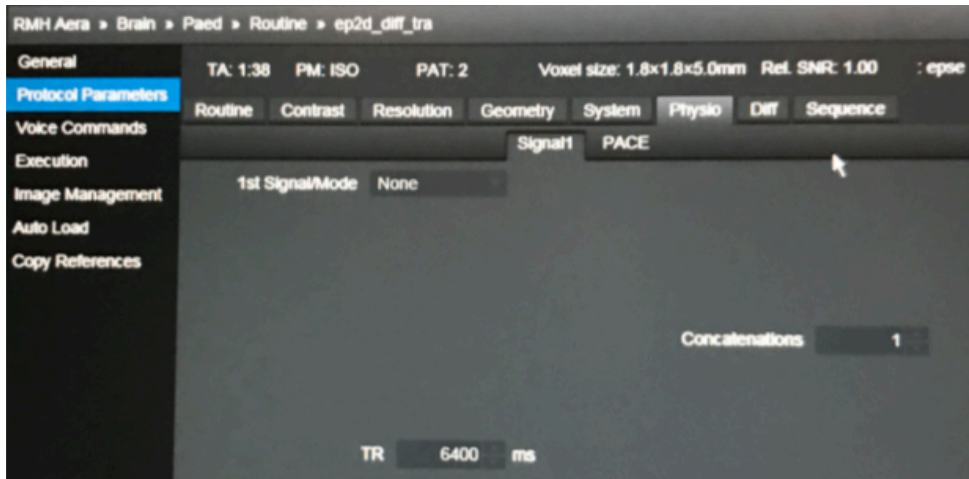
b: Protocol parameters of the DW-MRI of the head.
